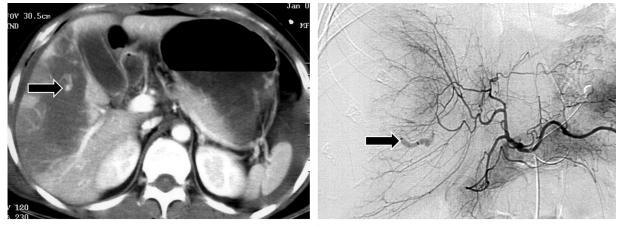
Active hemorrhage. (a) Arterial phase contrast-enhanced CT scan shows high-attenuation contrast material extravasation (arrow) within a massive hematoma in the posterior right hepatic lobe. (b) Radiograph obtained after injection of contrast material through a microcatheter in the right hepatic artery (arrowheads) shows active contrast material extravasation from the superior segmental branch of the artery (arrows).
